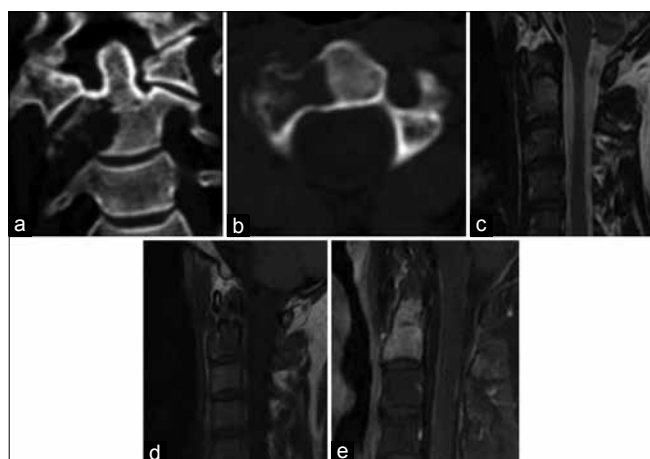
LCH of C2 in a 26-year old man. Coronal (a) reformatted computed tomography image scan revealed that vertebrae of C2 bone destruction, with C2 right rim bone cortex incomplete and sclerosis rim formation in the left of C2. Axial (b) reformatted image showed that right transverse foramen of C2 was involved. Sagittal T2-weighted (c) showed that C2 lesion was isointensity. Sagittal T1-weighted (d) images showed that C2 lesion was isointensity. On sagittal (e) gadolinium-enhanced T1-weighted image showed the significant enhancement of C2 lesion
